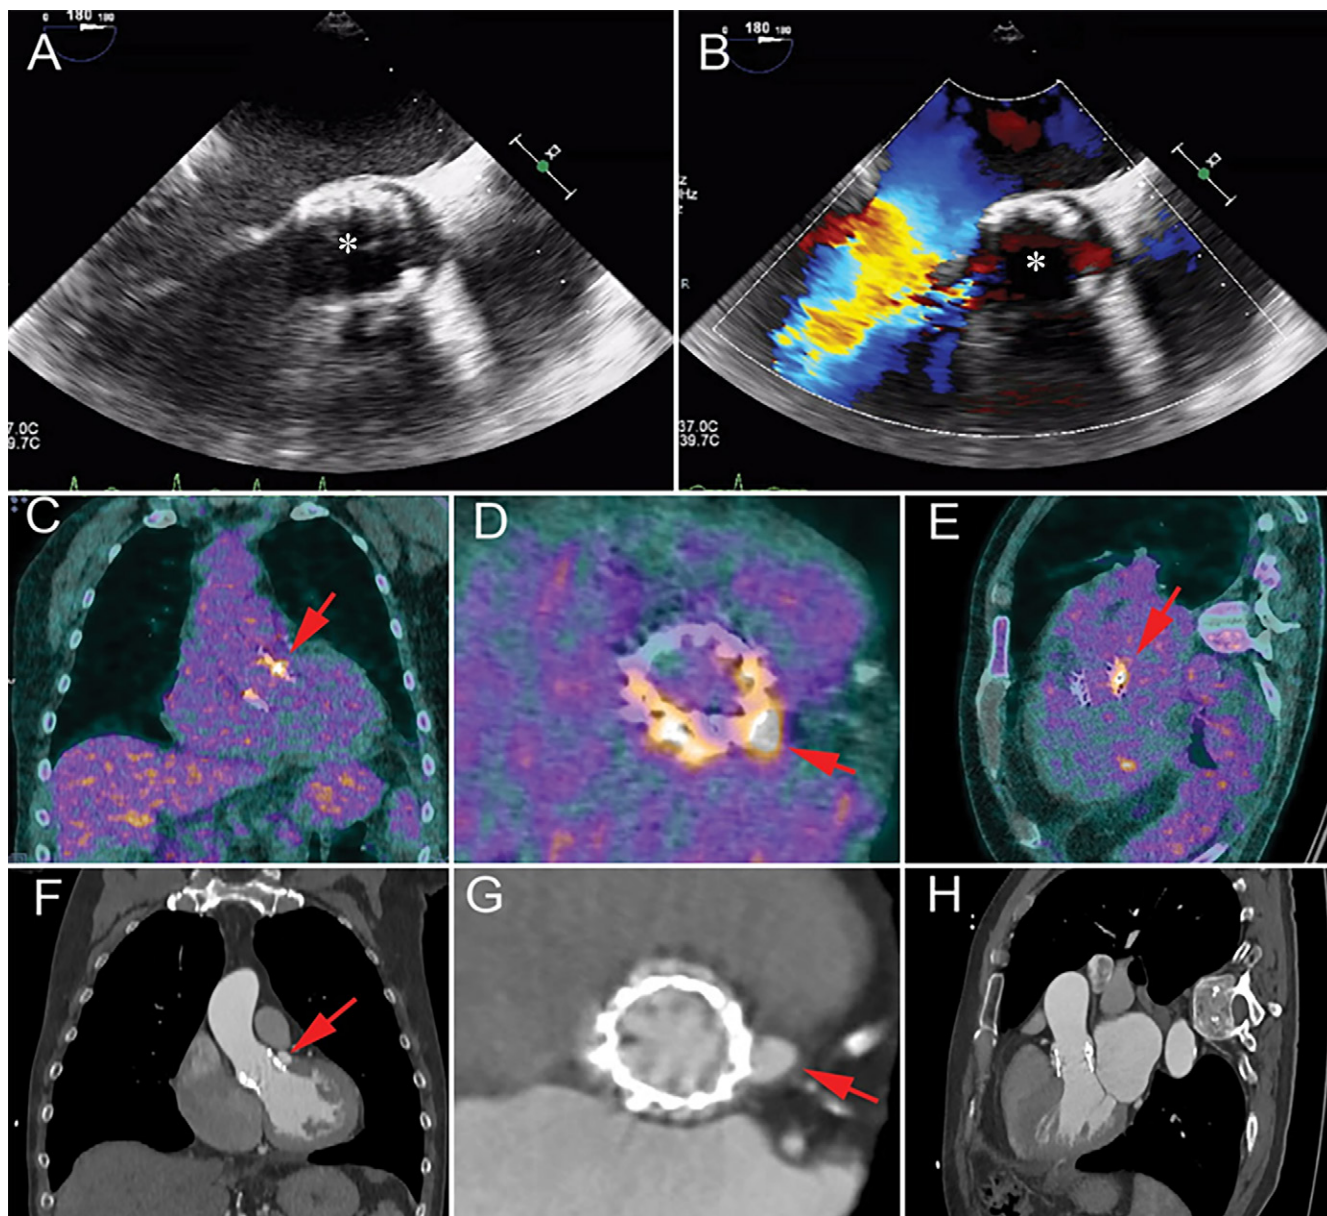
Images show a 62-year-old man with a history of transcatheter aortic valve replacement (TAVR) 6 months prior to presentation with fever and blood cultures positive for *Streptococcus pneumoniae*. A, B, Transesophageal echocardiography images show a TAVR (*) with no signs of endocarditis. C–E, Coronal, valve short-axis, and three-chamber images from fluorine 18 fluorodeoxyglucose (^{18}F -FDG) PET/CT performed 3 days after echocardiography show focal ^{18}F -FDG uptake near the region of the left coronary cusp (arrows). F–H, Contrast-enhanced CT angiography images obtained after 6 weeks (patient was treated with antibiotics) show a pseudoaneurysm (arrows) at the site of aortic annulus in the same ^{18}F -FDG uptake region.
